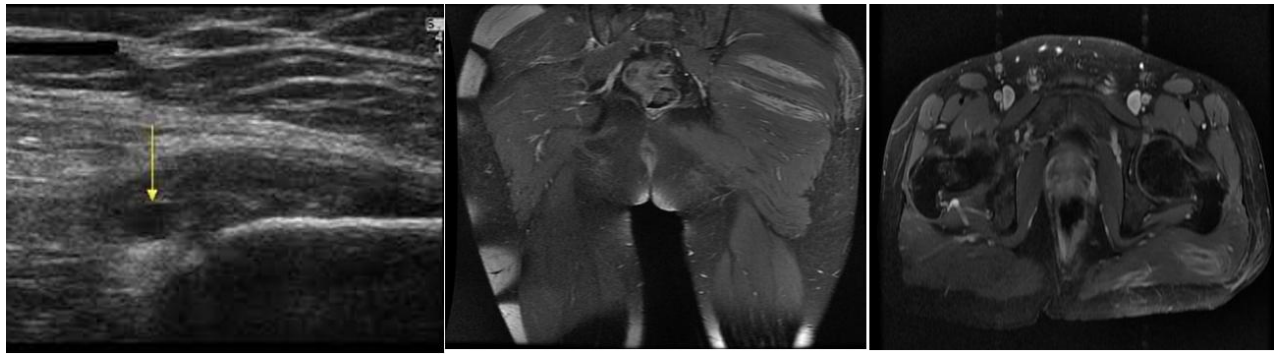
Showing high signal T2 strips of linear injury on MRI images, while edematous hypoechoic on superficial ultrasound scan on same anatomical plane with evident tenderness on probing.
